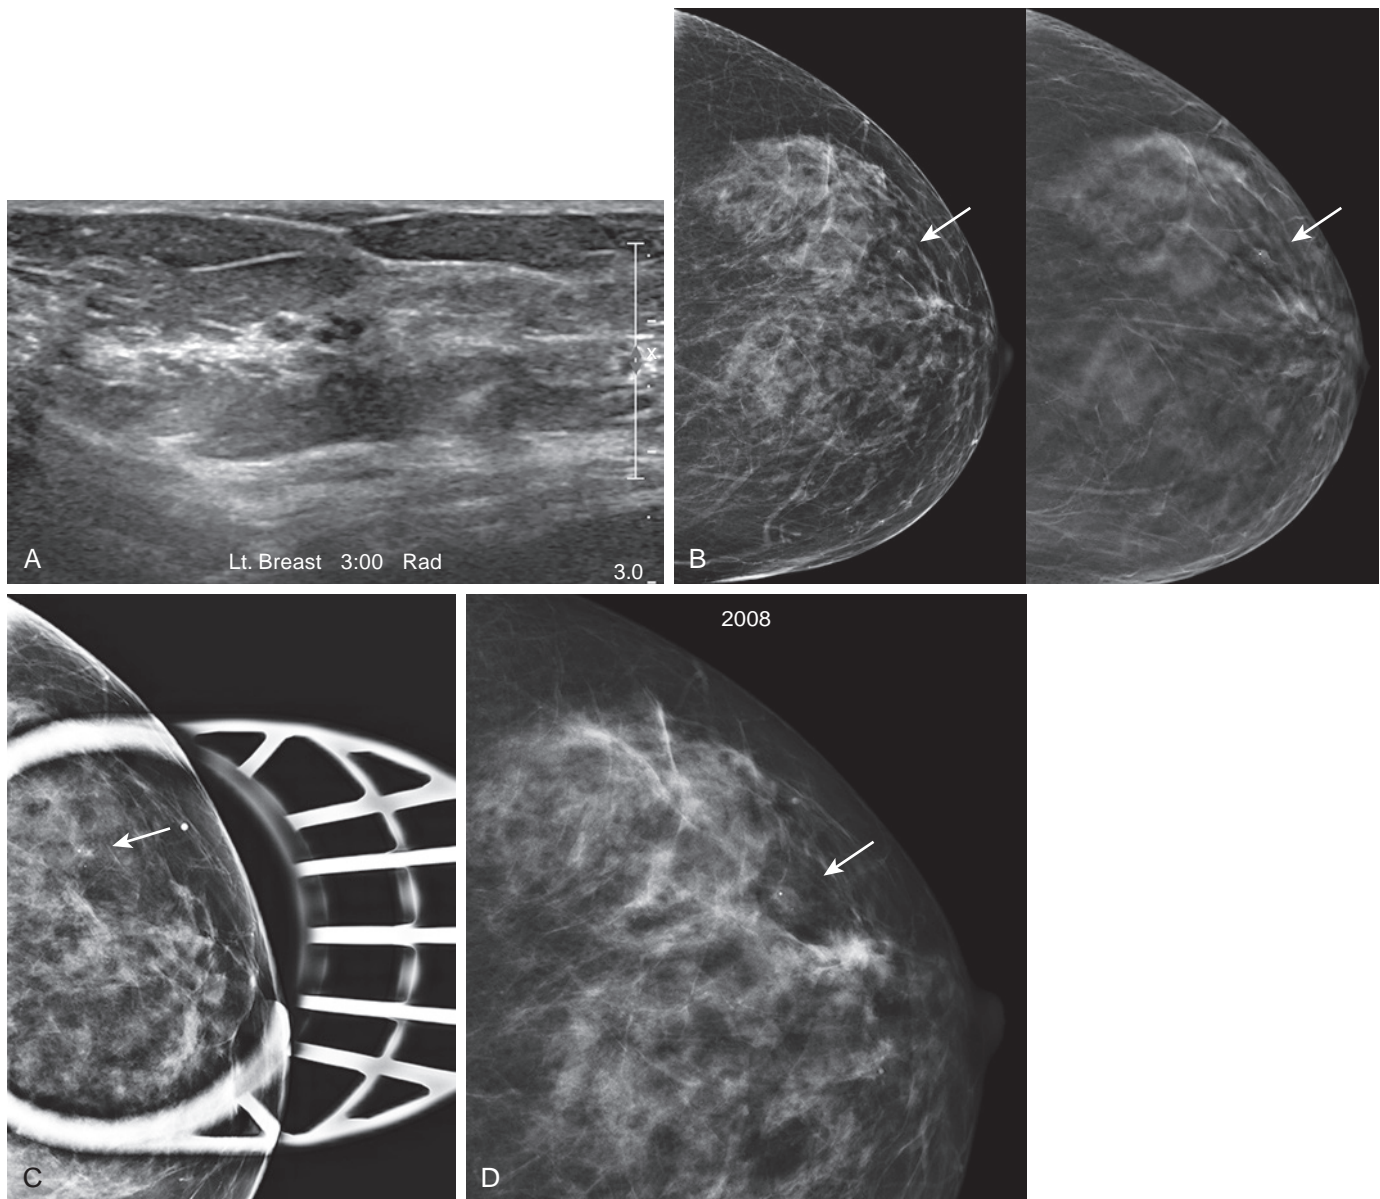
(A) Screening ultrasound in a 63-year-old woman with heterogeneously dense breasts reveals a small lobulated mass in the left 3-o'clock position. (B) Review of a recent mammogram (reported as normal and stable) shows a small mass in the lateral breast (arrow) seen well on the tomosynthesis image, with an associated calcification. (C) A BB was placed on the skin over the sonographic finding, and a spot tomosynthesis view was obtained. (D) The finding was noted to correspond to the stable mass, not as obvious on two-dimensional imaging but seen to be present on multiple mammograms dating back to at least 2008.
